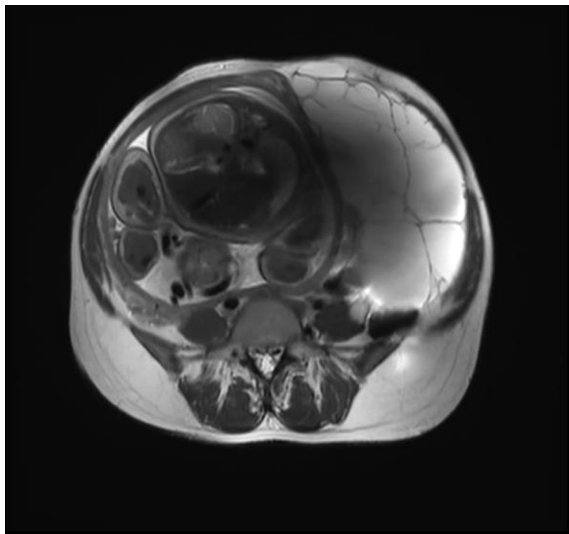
MRI showing large multiseptated cystic adnexal lesion suggestive of lymphangioma.
